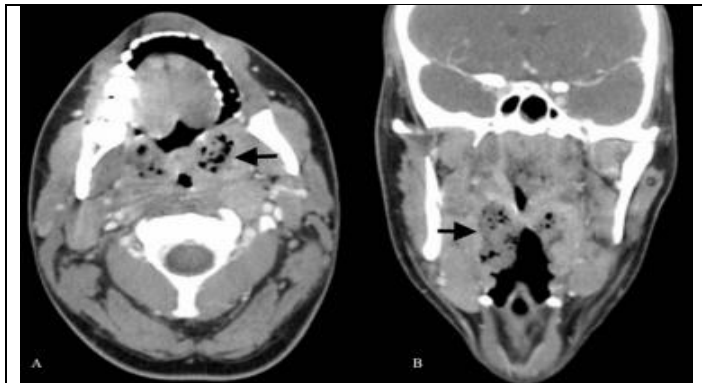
Soft tissue emphysema has been found on a head CT in the tonsillar region. Views in the axial (A) and coronal (B) views
